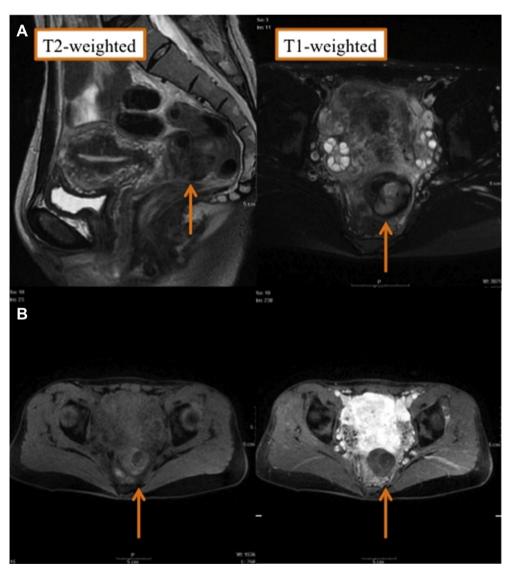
Magnetic resonance imaging (MRI) at her initial visit. (A) A 37-mm-sized mass (arrows) is delineated in the Douglas pouch. (B) Note that the mass lacks contrast enhancement.
